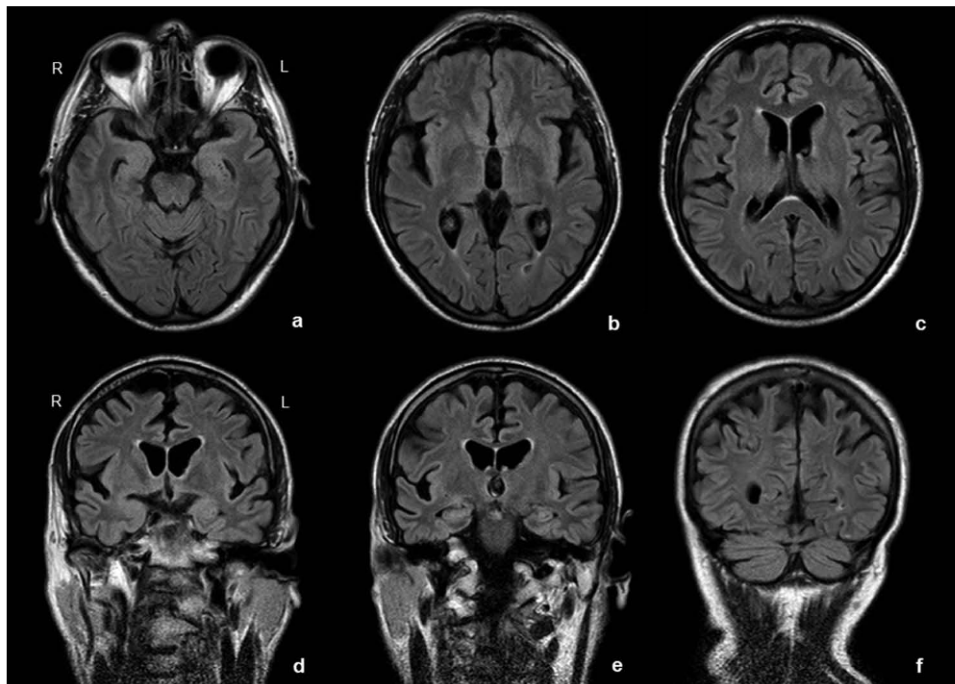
Brain magnetic resonance imaging (MRI), axial (a–c) and coronal (d–f) FLAIR sequence: showed right greater than left cortical atrophy in frontal, temporal and parietal regions. R = right, L = left.
